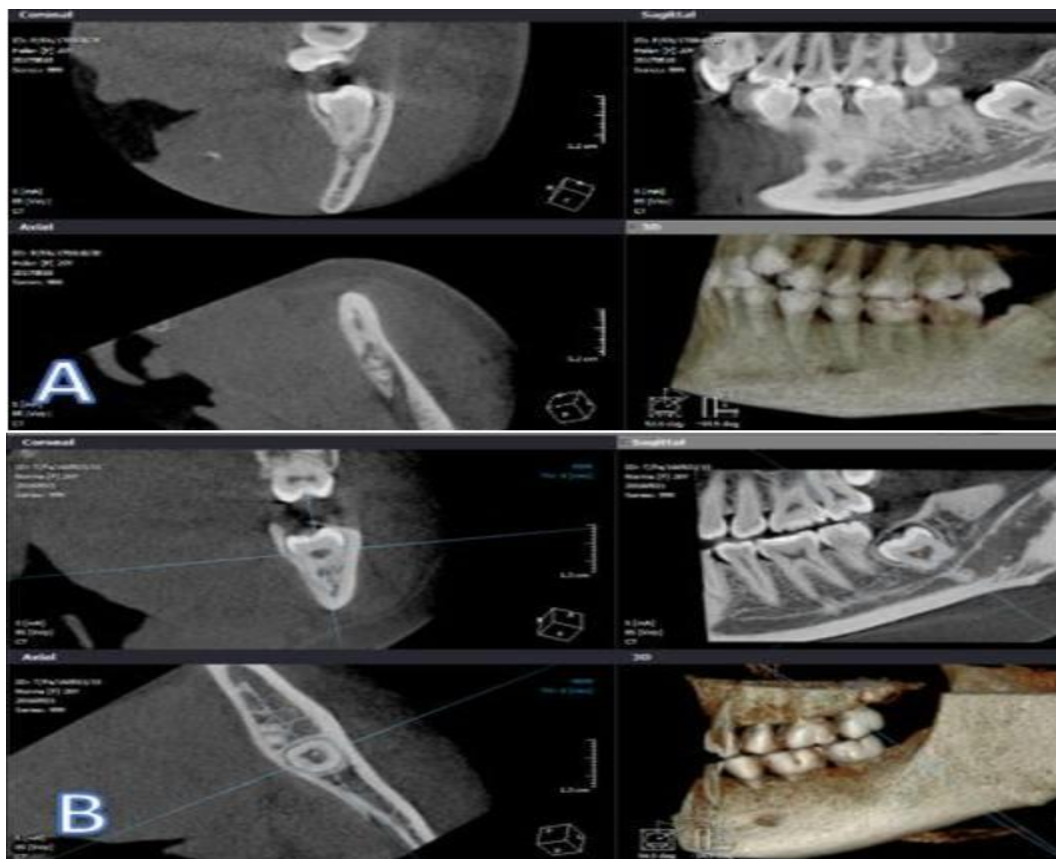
Radiological evaluation of impacted mandibular third molar CBCT radiograph [L.H. Matzen, A. Wenzel, 2015].
